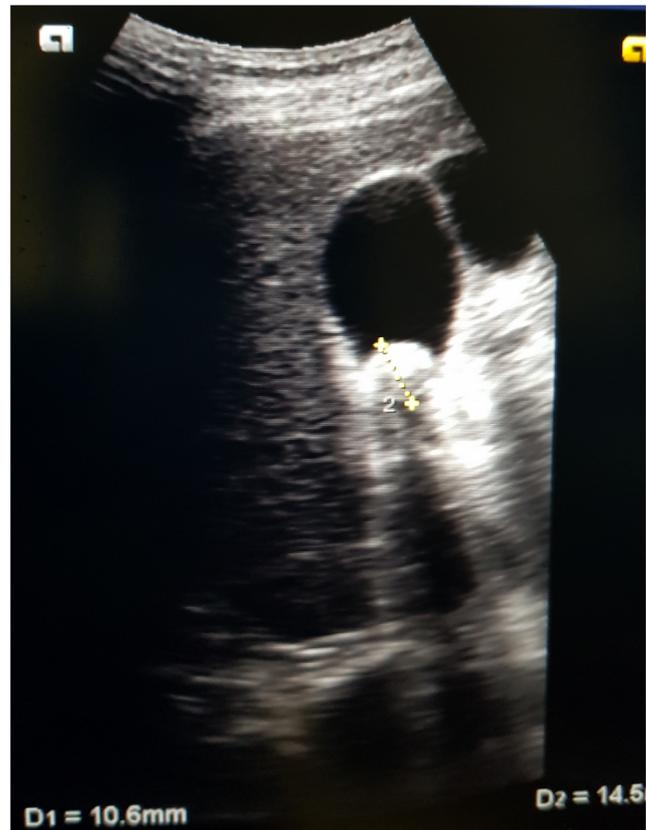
Transabdominal ultrasound showing the distended gallbladder containing the gallstone with a communicating cystic lesion adjoining it
